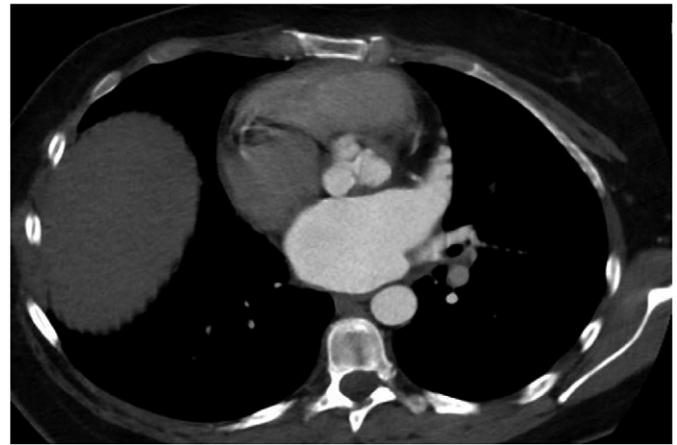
The morphology of the aortic valve was well demonstrated to be trileaflet on multi-detector computed tomography (contrast-enhanced axial image).
